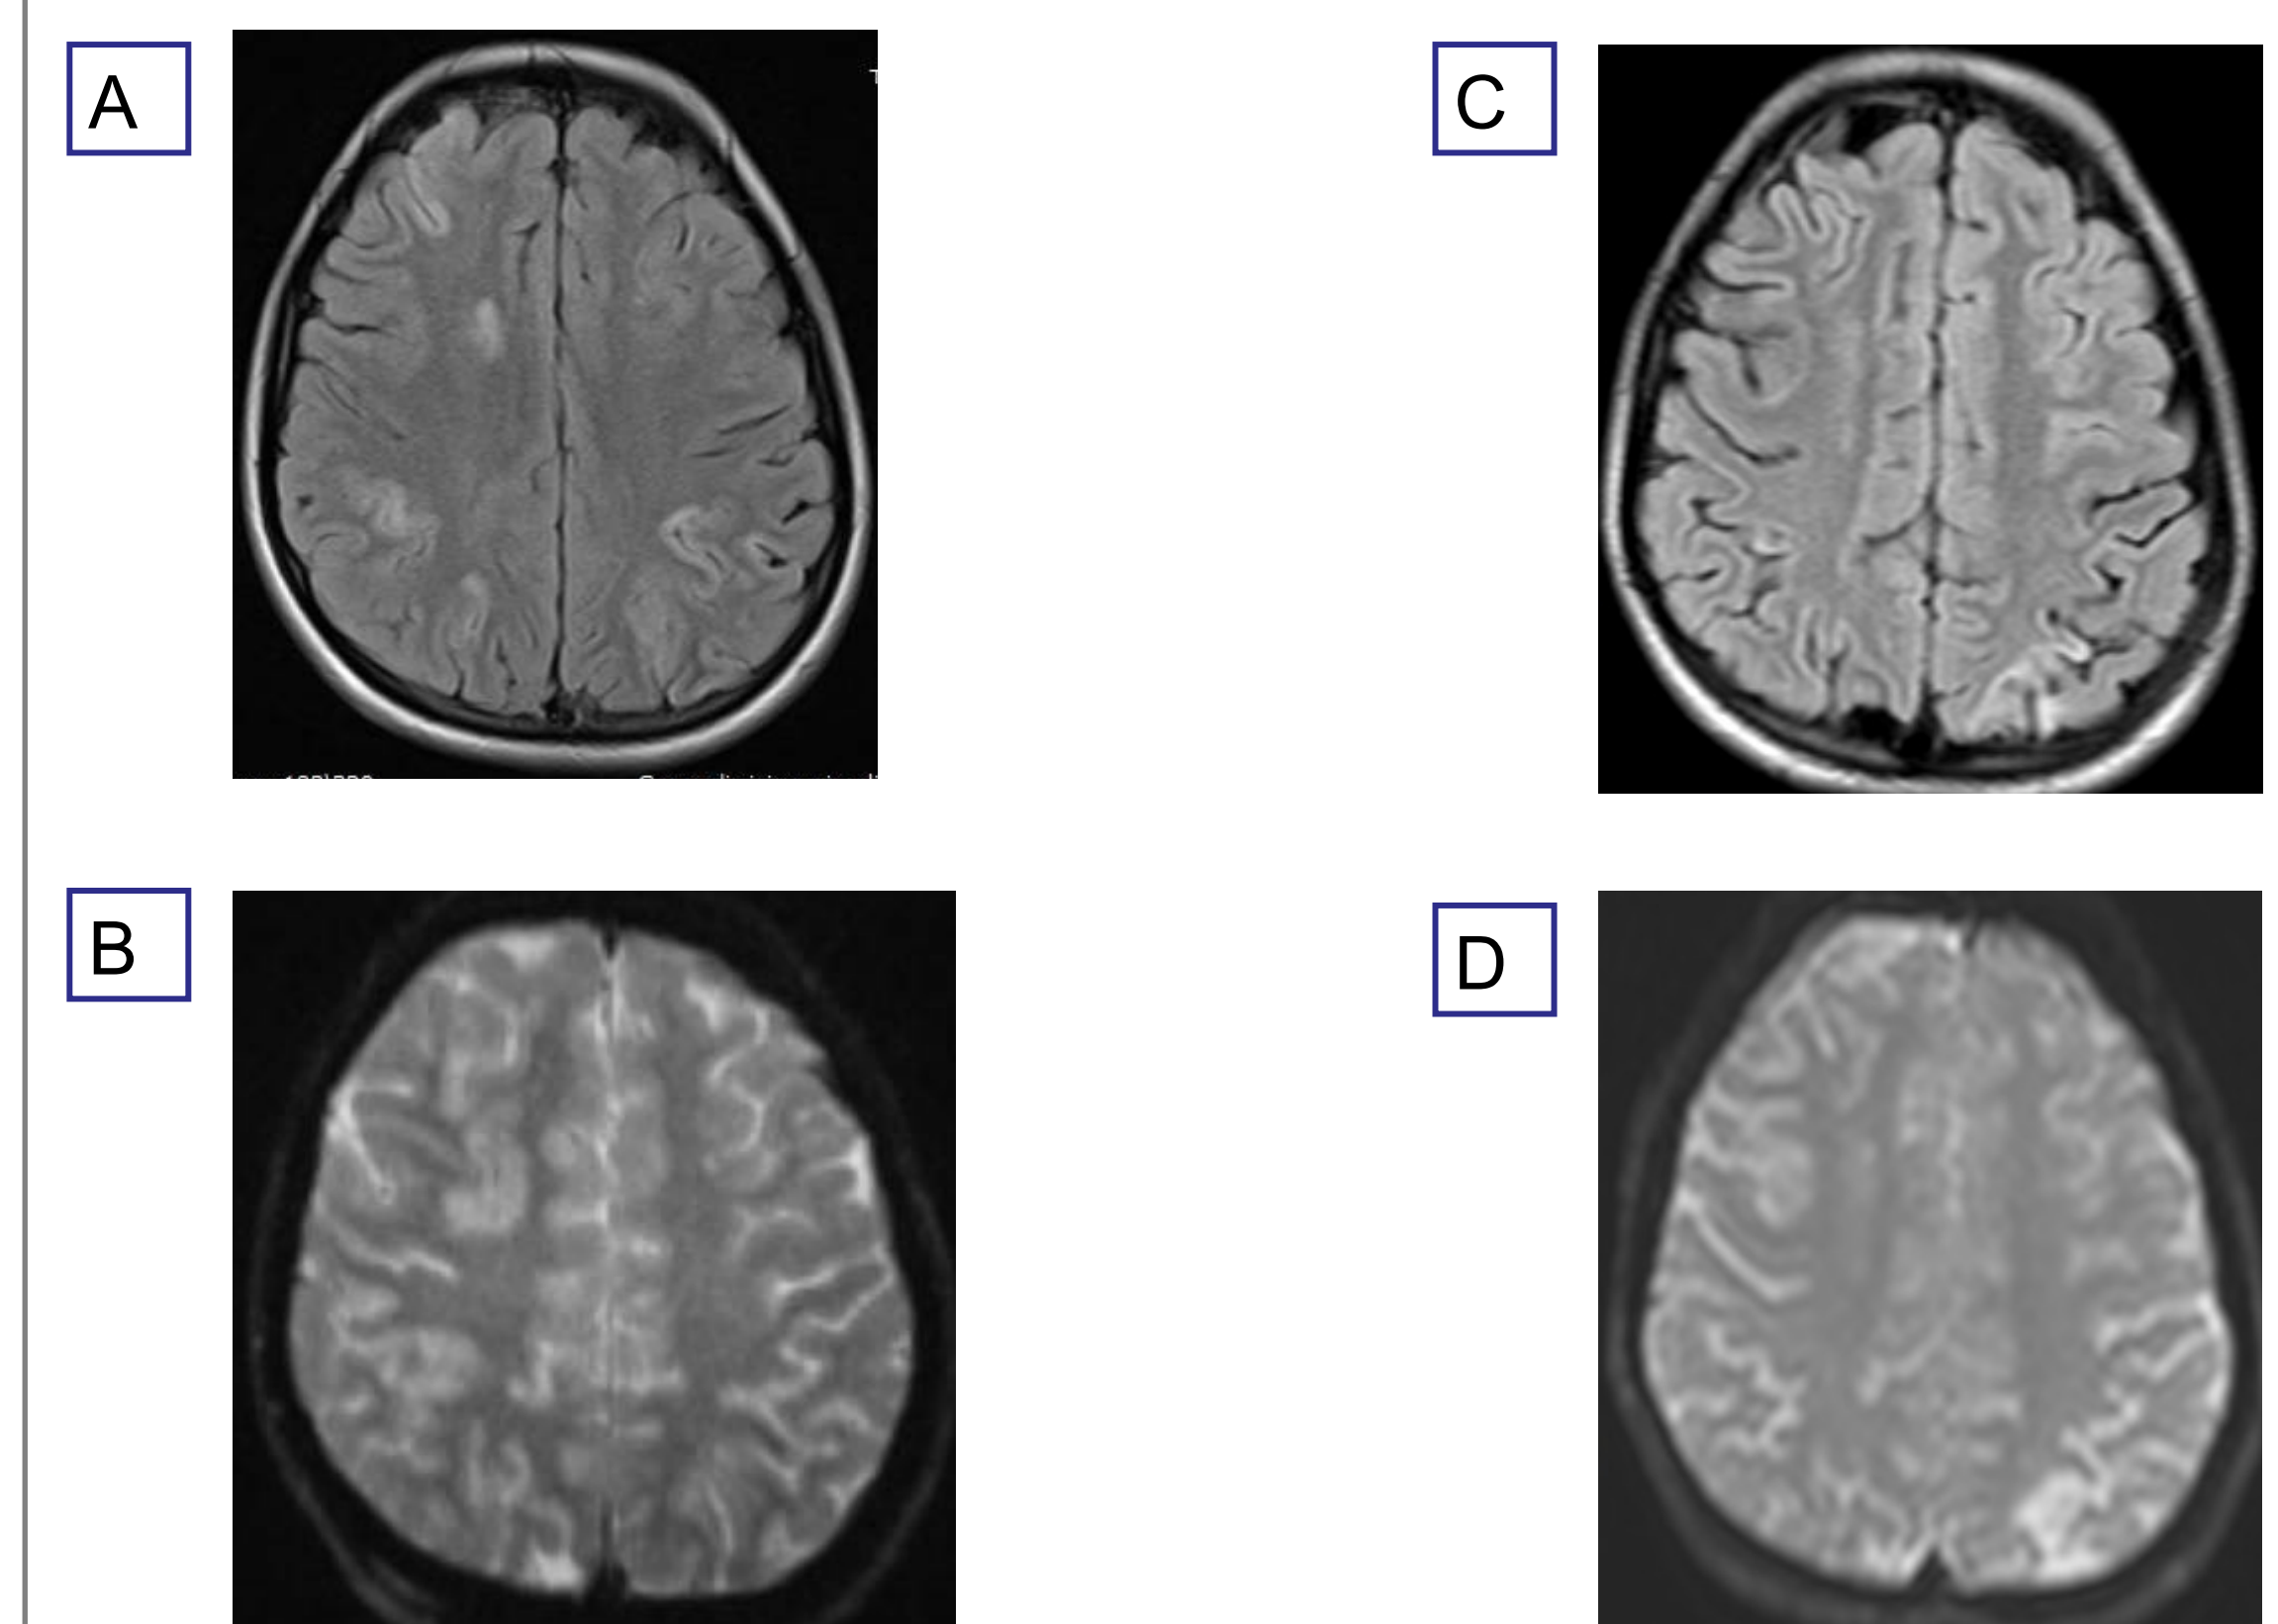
Panel A : FLAIR weighted coronal Brain MRI at presentation. Panel B : DWI weighted coronal Brain MRI at presentation. Panel C : FLAIR weighted coronal Brain MRI at six month follow-up. Panel D: DWI weighted coronal Brain MRI at six month follow-up
